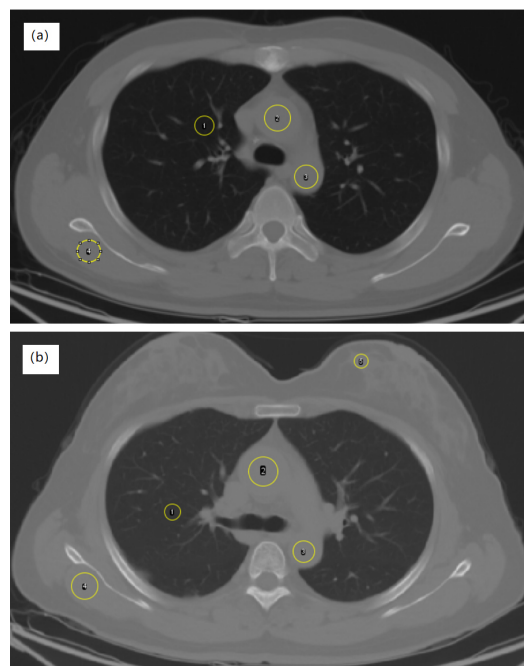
Demonstration of ROI selection in chest CT for male (a) and female (b). The locations of ROIs 1-4 are the lungs, mediastinum, aorta, and muscles, respectively, and 5 represents the female breast.
